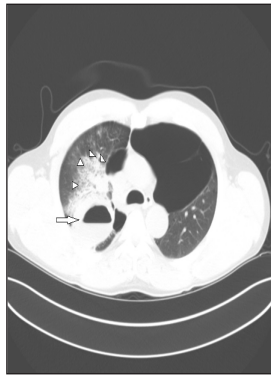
Computed tomogram chest (without contrast), axial view with lung window, showing air fluid level (arrows) with surrounding parenchymal infiltrates (arrowheads). Extensive bullous emphysema of bilateral lungs is visible
